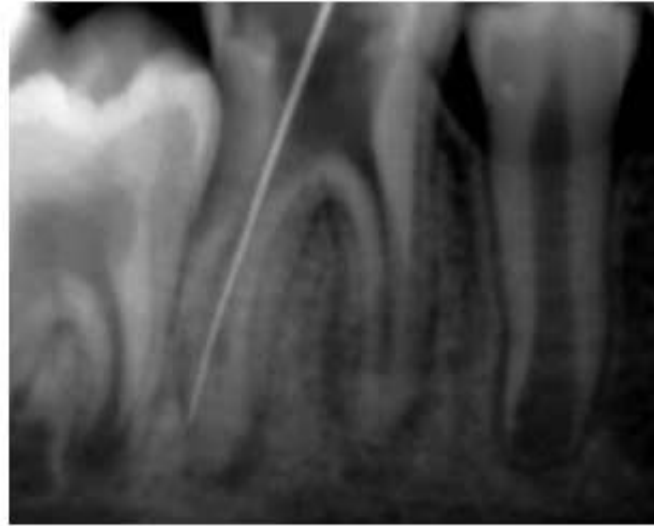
Radiograph showing perforation of distal canal molar of mandibular first molar
